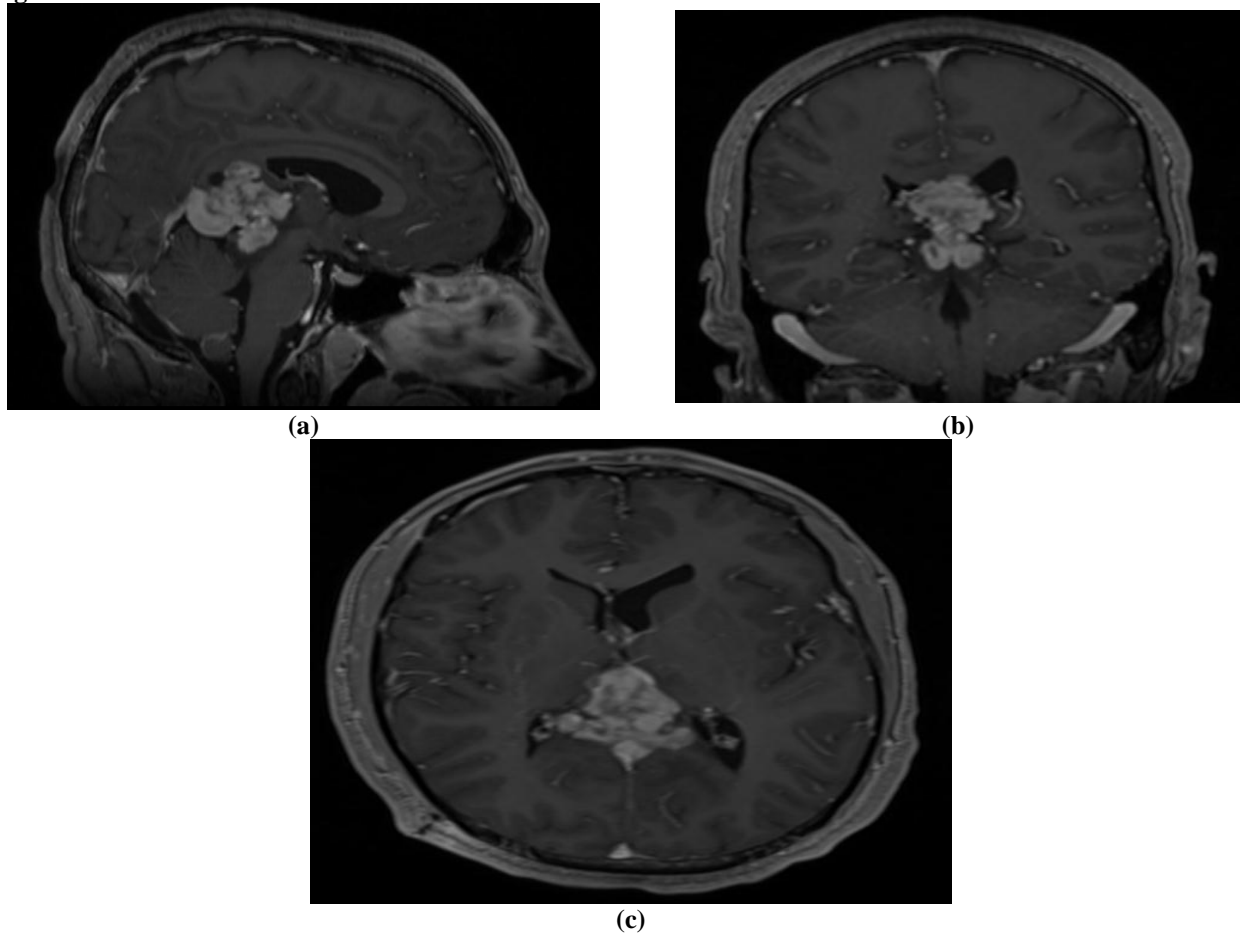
Initial T1 MRI (sagittal (a), coronal (b), axial section (c)) showing a tumor in the pineal region with obstructive hydrocephalus.
